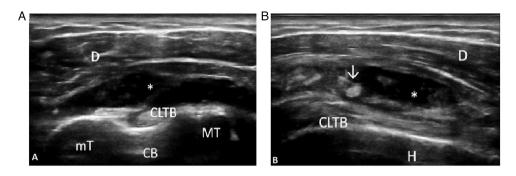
Transverse (A) and longitudinal (B) scan in gray scale of the long head of the biceps tendon, demonstrating anechoic moderate collection in the subacromial/subdeltoid bursa, with the presence of villonodular synovial proliferation in a 79-year old male patient (performed on a MyLabSix Ultrasound machine; Esaote SpA). mT, small tuberosity of the humerus; MT, big tuberosity of the humerus; CLTB, long head of the biceps tendon; CB, bicipital groove; *, collection; d, deltoid muscle; \downarrow , synovial proliferation.
